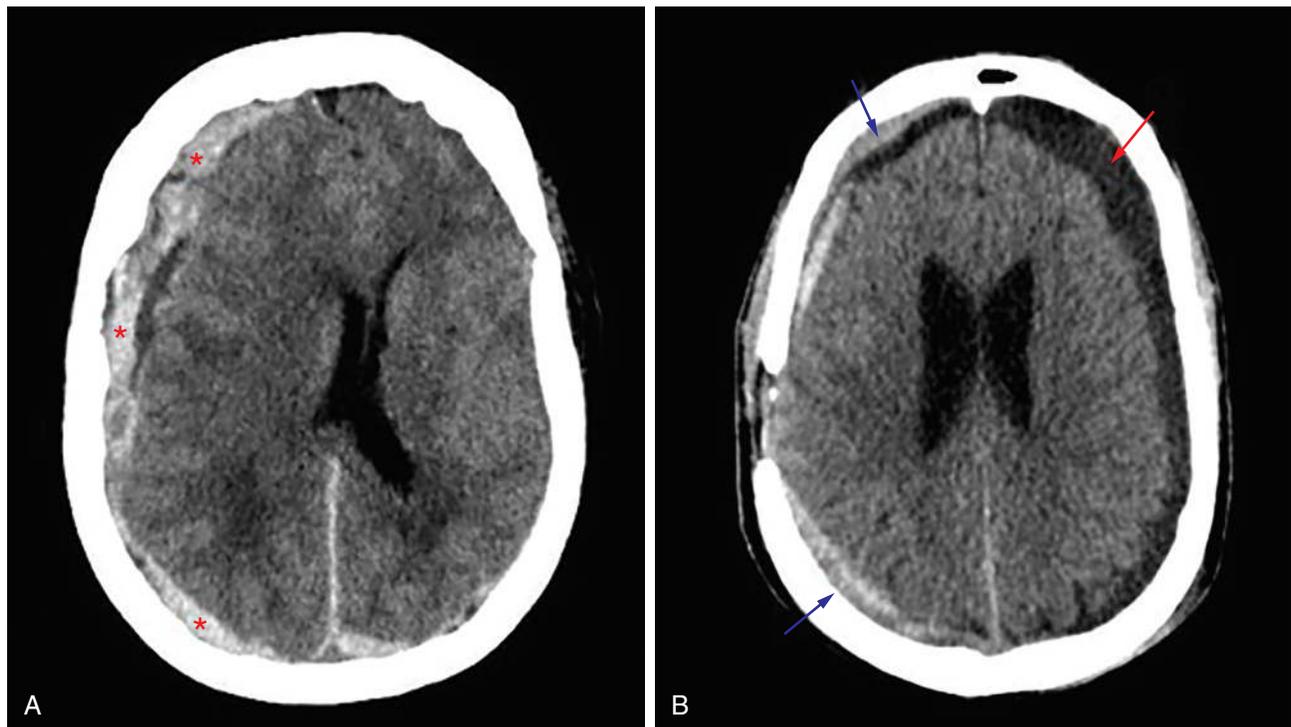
Evolution of intracranial hemorrhage on CT. A, Acute subdural hematoma appears as a crescentic extraaxial collection hyperdense to adjacent brain parenchyma (*red asterisks*). B, Subacute blood appears isodense to brain (*blue arrows*) and chronic blood appears hypodense to brain (*red arrow*) in this patient with mixed-age subdural hematomas.
